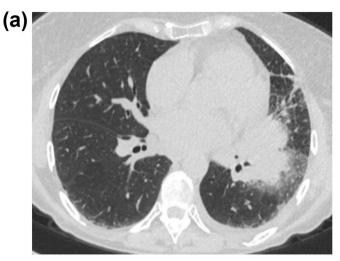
Chest CT scan on day 9 showed rounded infiltrates measuring 2–3 cm in diameter in the left upper and lower lobe and a spiculated infiltrate measuring 1.5 cm in the right upper lobe, suggestive of a mold infection (1A). On day 81, the lesion in the right upper lung had evolved to a cavern about 2 cm in diameter (1B). After 14 months of antifungal therapy, a nodule measuring 9×5 mm remained of the previous cavern in the right upper lobe (1C).
